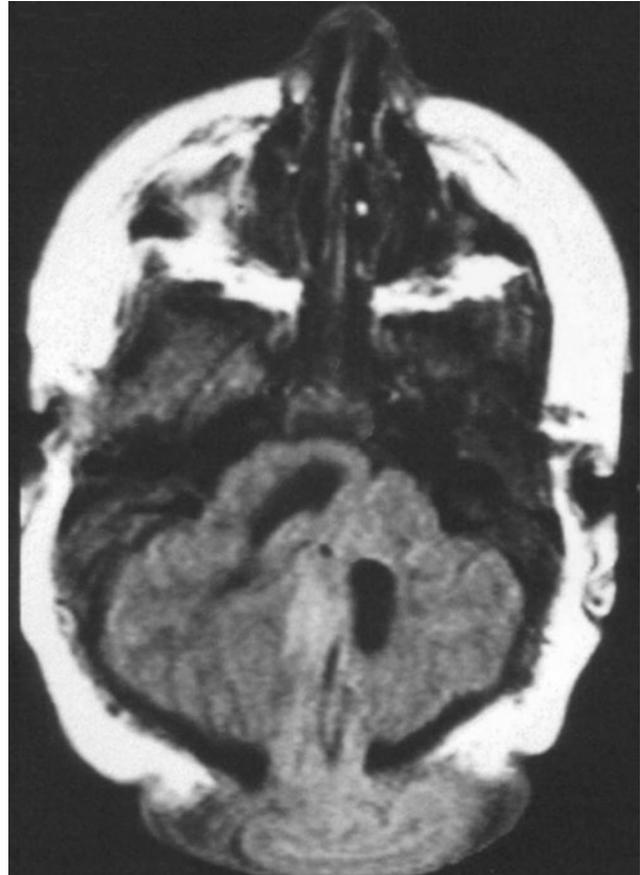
Axial T2-weighted magnetic resonance image of a patient with an occipital encephalocele shows marked dysplasia of the posterior fossa contents.
